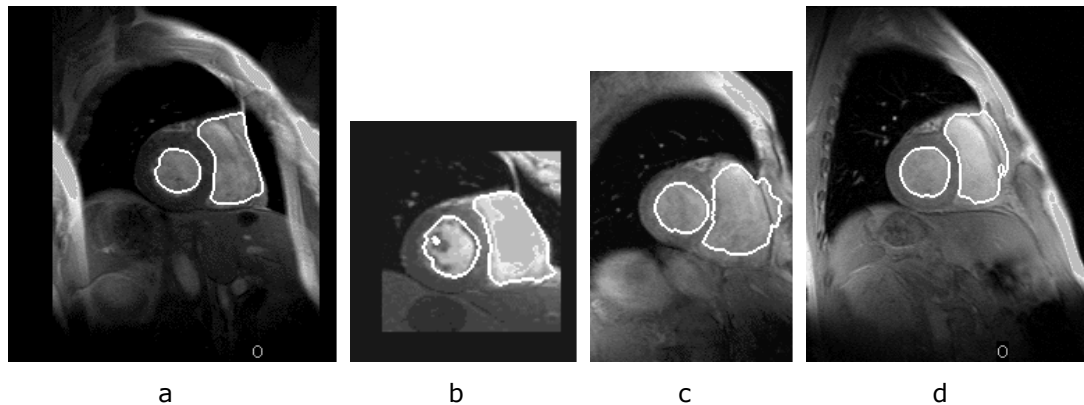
Example segmentation of adult cardiac MR images (2D) using the MSSCD algorithm. The LV appears on the *left hand side* of each image.
